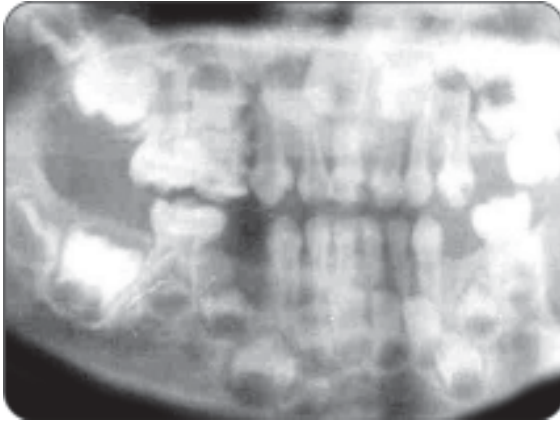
X-ray reveals dentigerous cyst developing in relation to lower first molar tooth
